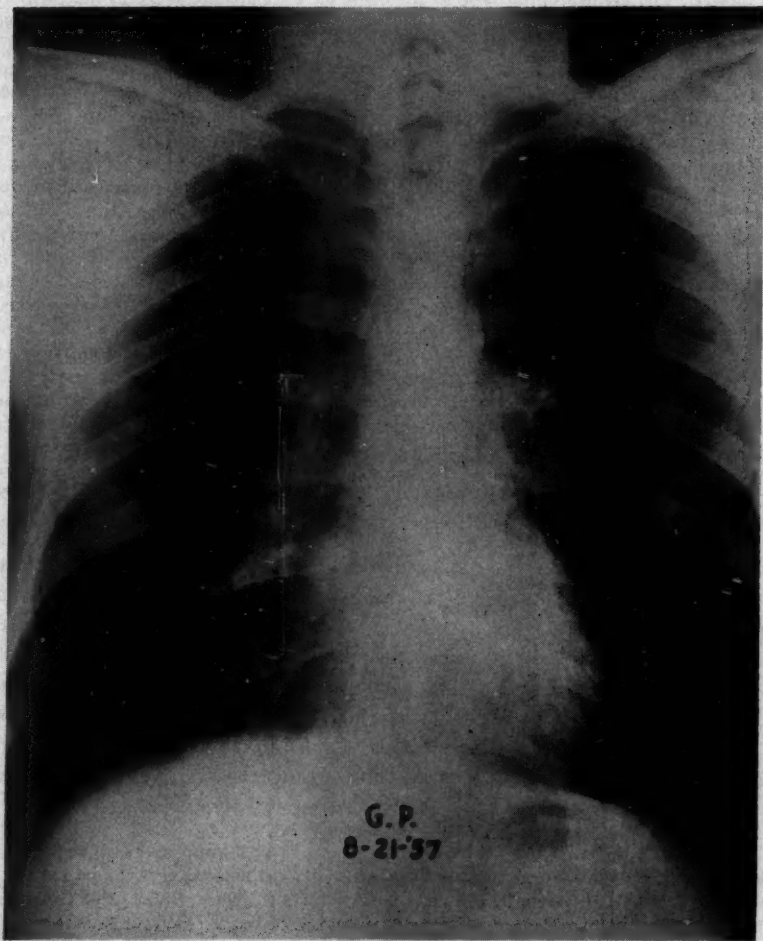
Chest x-ray of case 8 taken one year after onset. The densities have almost entirely cleared.
